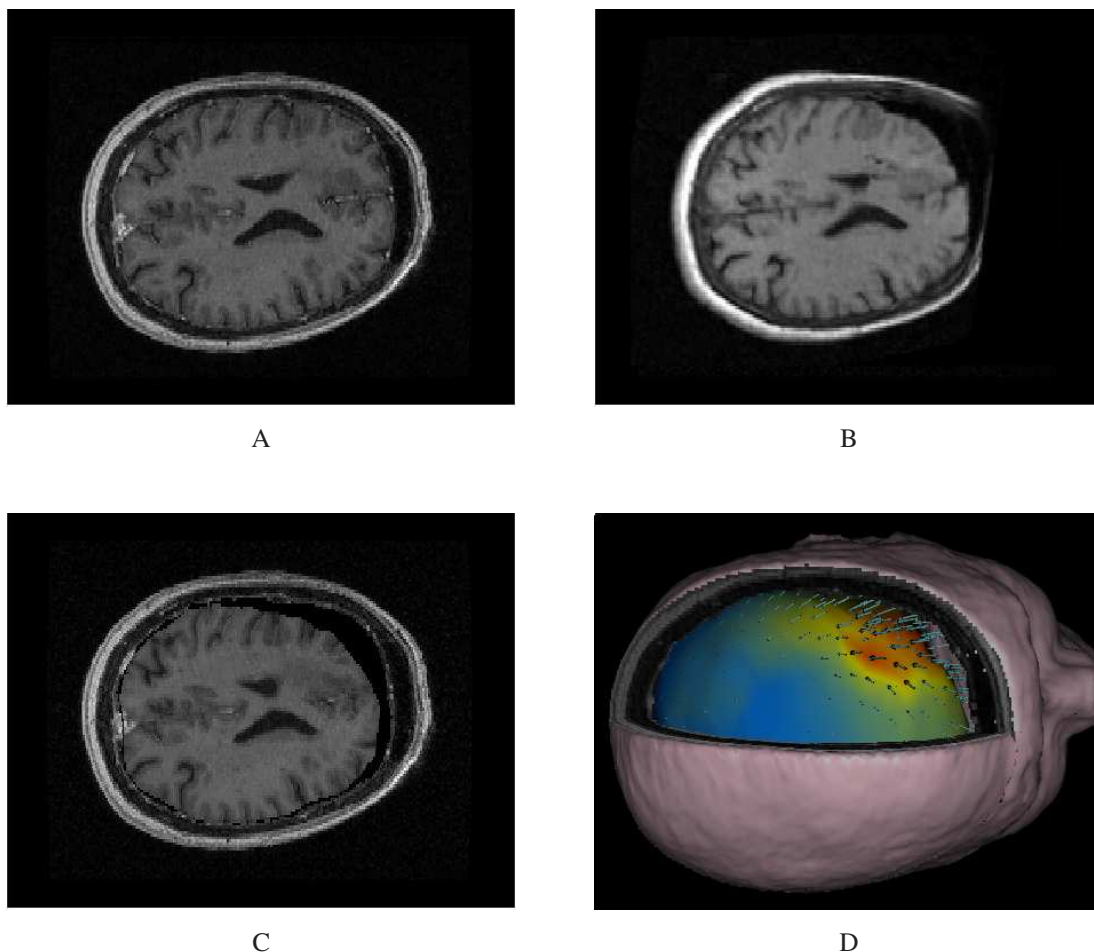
Biomechanics-based intraoperative non-rigid tracking of brain tissues during surgery. (A) Pre-operative T1 weighted MR image of the patient's brain. (B) Intra-operative T1 weighted MR image during a tumor resection procedure. (C) Warping of the pre-operative image on the intra-operative image. (D) 3D visualisation of the displacement field of the brain surface.
